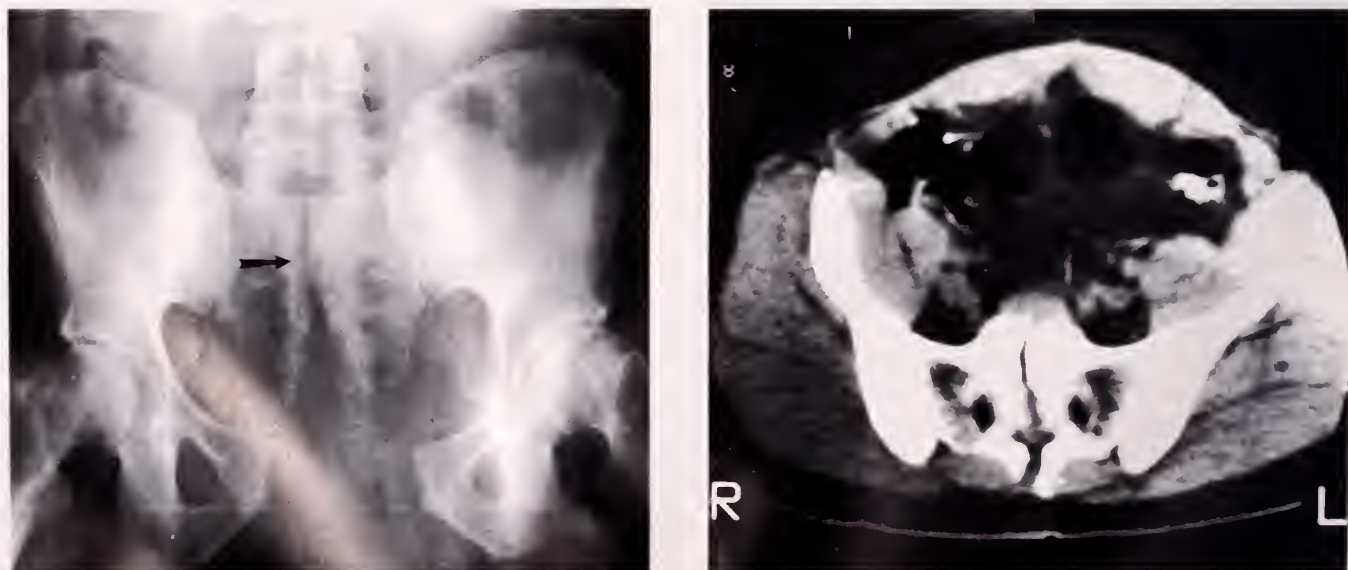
(A) AP radiograph of the pelvis showing an unusual antero-compression type injury with marked diastasis of the pubic symphysis associated with midline vertical sacral fracture. (B)CT of the pelvis at the level of the upper sacrum shows the midline vertical sacral fracture. (C)Combining internal fixation of the sacral component with external fixation of the pubic diastasis gave the patient a good result.
